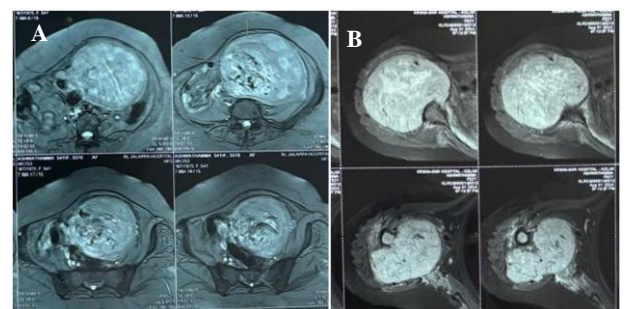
(A) MRI scan of pelvis showing the lesion arising from the uterus and (B) MRI scan of shoulder showing the expansile lesion.
